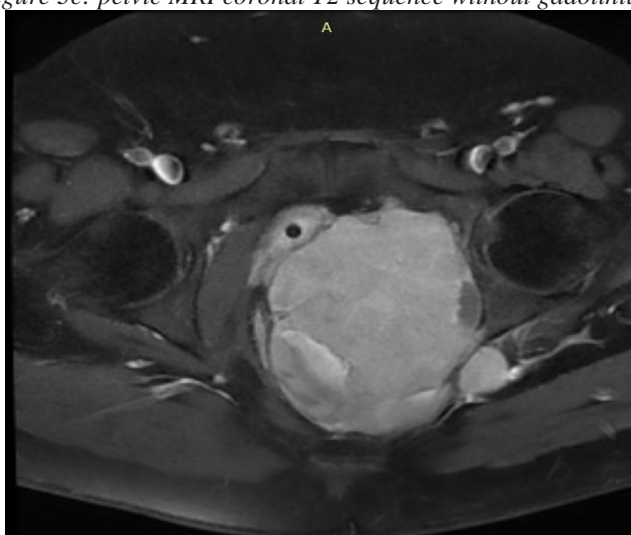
pelvic MRI axial T1 FAT SAT sequence with gadolinium
